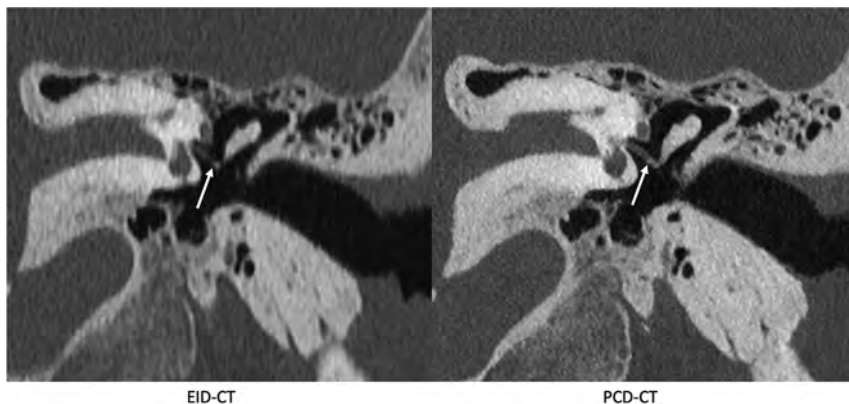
The incudostapedial joint (*arrows*), shown on EID-CT (*left*) and PCD-CT (*right*) images. The joint was one of several anatomic structures specifically graded using a 5-point Likert score, with higher scores favoring the quality of the PCD-CT images. The images reformatted in this plane were generated by a nonreviewer radiologist to demonstrate certain anatomic features but were not used by the readers to score image quality.
